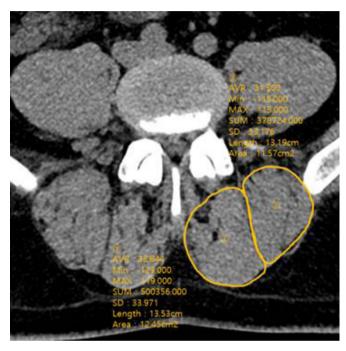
The cross-sectional area (CSA) of multifidus and erector spinae muscles was measured in the mid-intervertebral index disc level at the axial CT image.
